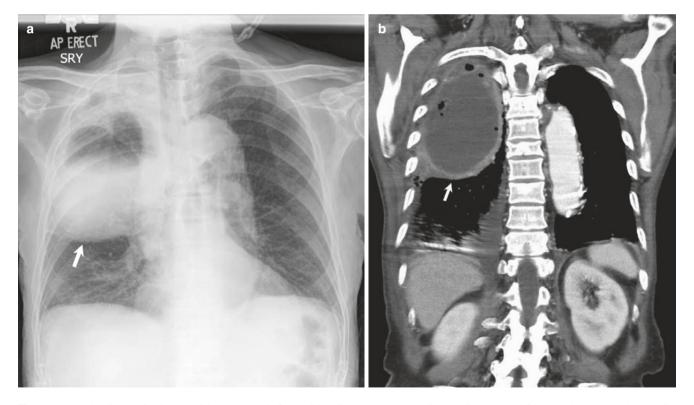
Bulging fissure sign in necrotizing pneumonia from *Klebsiella pneumoniae*. (a) Chest radiograph and (b) coronal contrast-enhanced CT image of a middle-aged adult showing right upper lobe consolidation, bulging the minor fissure
